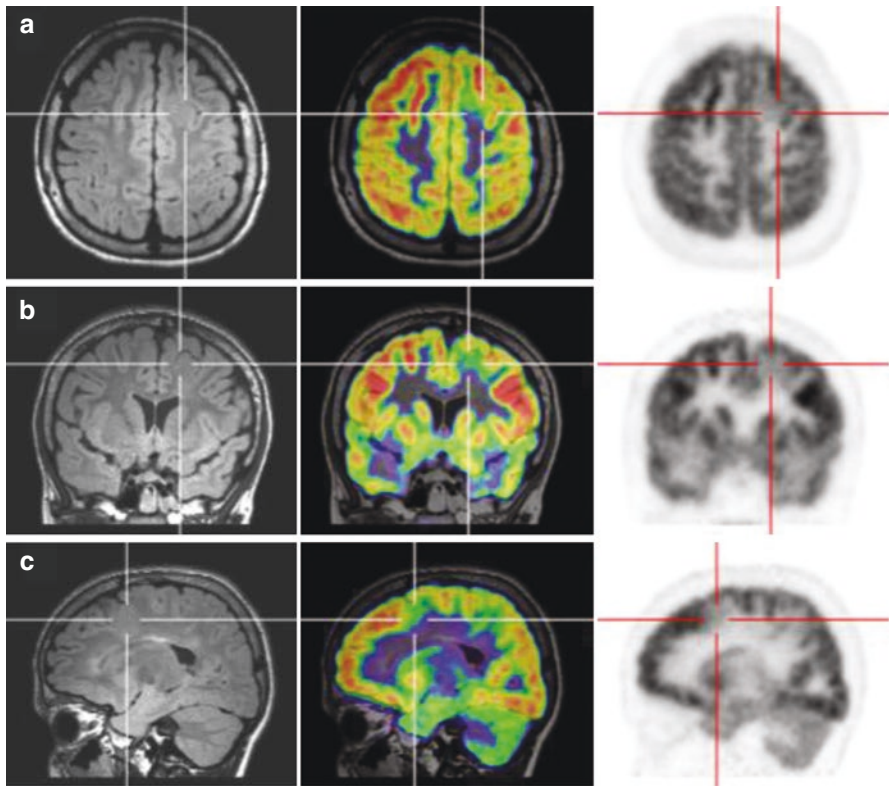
Extratemporal lobe epilepsy. (a) axial view; (b) coronal view; (c) sagittal view of MRI T2-weighted fluid-attenuated inversion recovery (FLAIR), PET/MR fusion, and FDG-PET. Left frontal superior focal cortical dysplasia discretely hyperintense in the FLAIR sequence (white axes in the first column) and isointense in T2 and T1. PET/MR fusion and FDG-PET demonstrated a hypometabolism of the lesion (white and red axes in the second and third columns, respectively)
